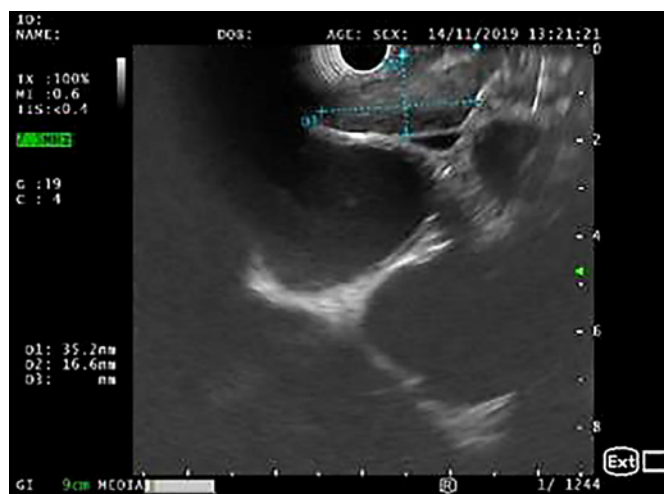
EUS (linear array, transesophageal view – station 7): crescent-shaped lymph node, with 35 × 17 mm and a hypoechoic homogeneous echo pattern.
